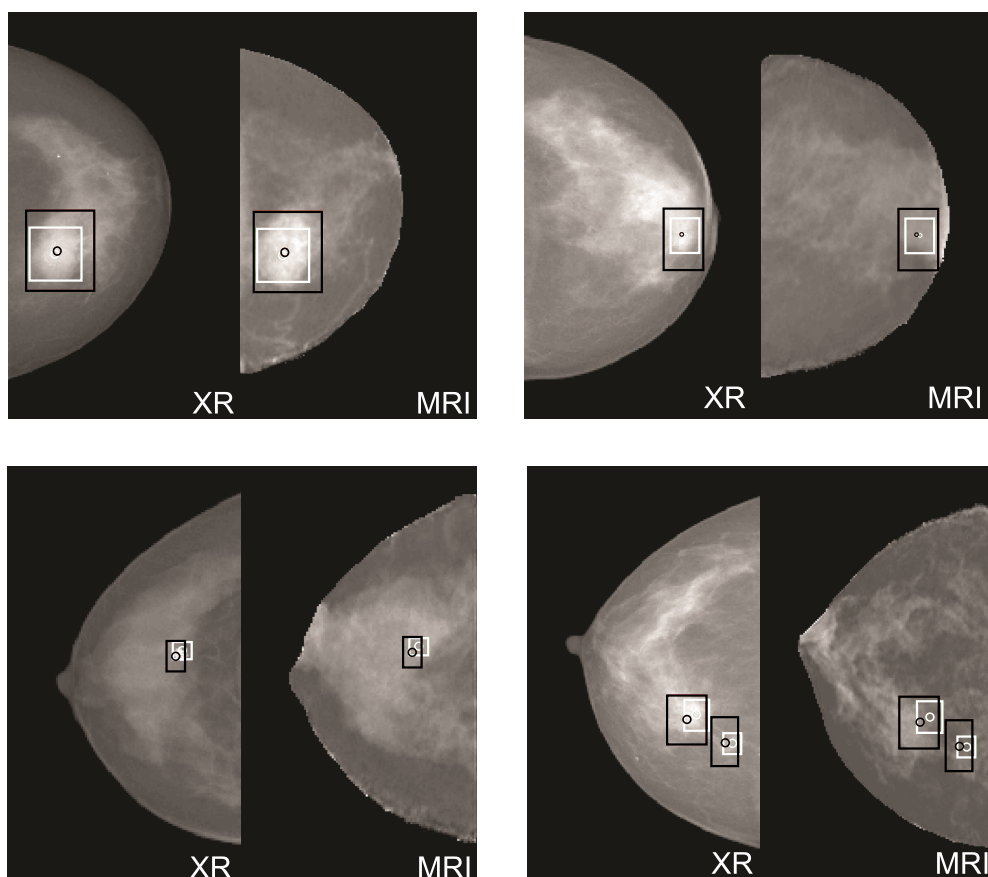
Registration results of four patients: mammogram (left) and projection of registered MRI (right). The lesion marking is represented by a white rectangle (mammogram annotation) respectively a black rectangle (MRI annotation).
